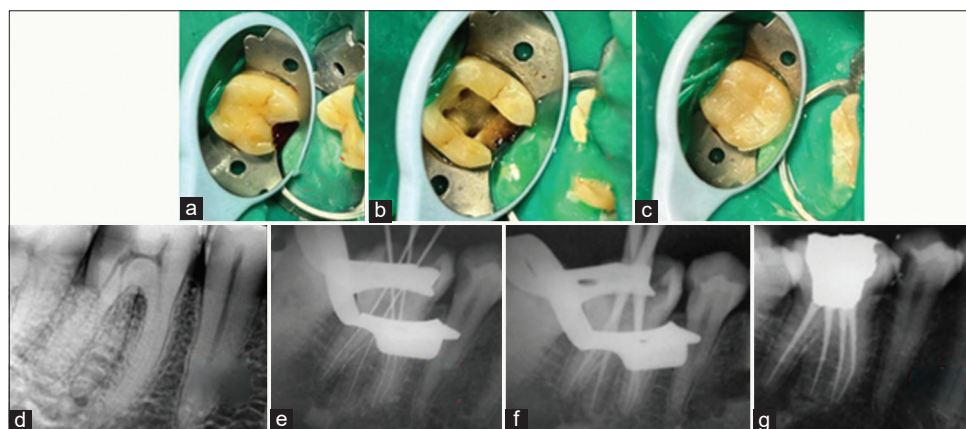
(a) Pre-operative; (b) access cavity preparation; (c) post-endo restoration; (d) pre-operative radiograph; (e) working length determination; (f) master apical cone radiograph; (g) obturation (case 1)
